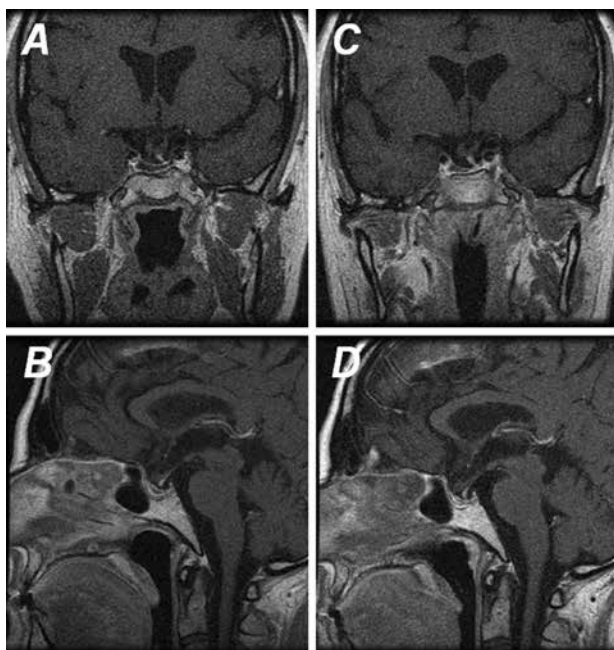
Gadolinium-enhanced T1-weighted sagittal and coronal MRI three months (A, B) and 60 months (C, D) after the apoplectic event showed complete resolution of the pituitary tumour. Secondary empty sella with left, lateral displacement of the pituitary stalk and flattened pituitary gland are seen. Optic chiasm is distorted and drawn to the sella
